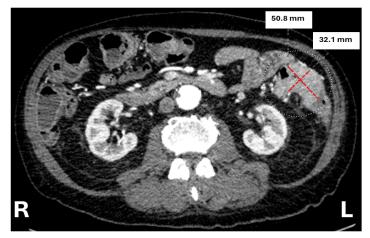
Abdominal CT with triple phase enterography
